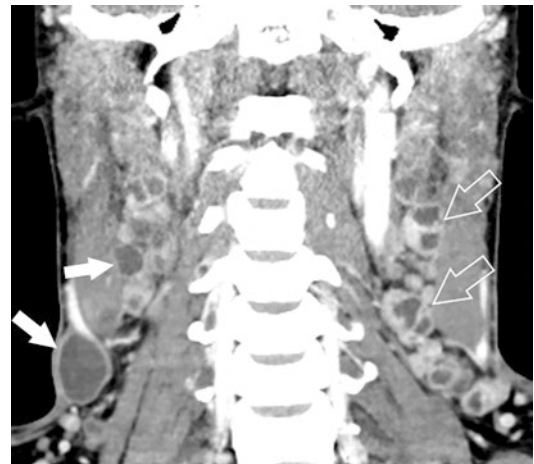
Necrotic lymph nodes in tuberculous lymphadenitis. Coronal contrast-enhanced CT image shows bilateral cervical lymphadenopathy. Some of the lymph nodes show multiloculated necrosis with irregular, thick rim enhancement (open arrows), while some of them show uniloculated necrosis with smooth, thin rim enhancement (solid arrows)
